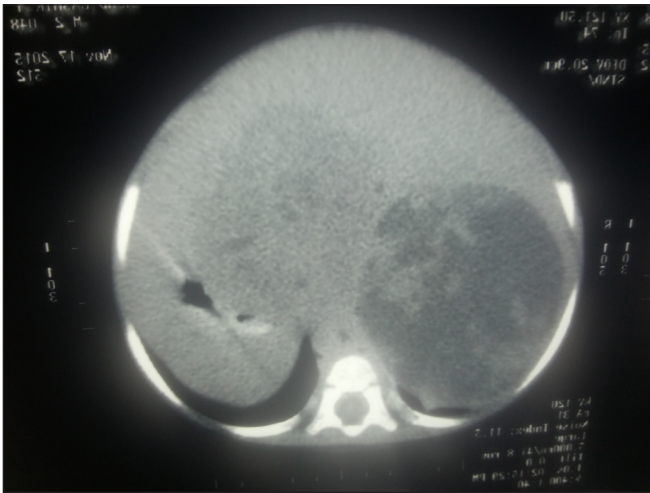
Computed tomography abdomen showing a retroperitoneal suprarenal hypodense mass
